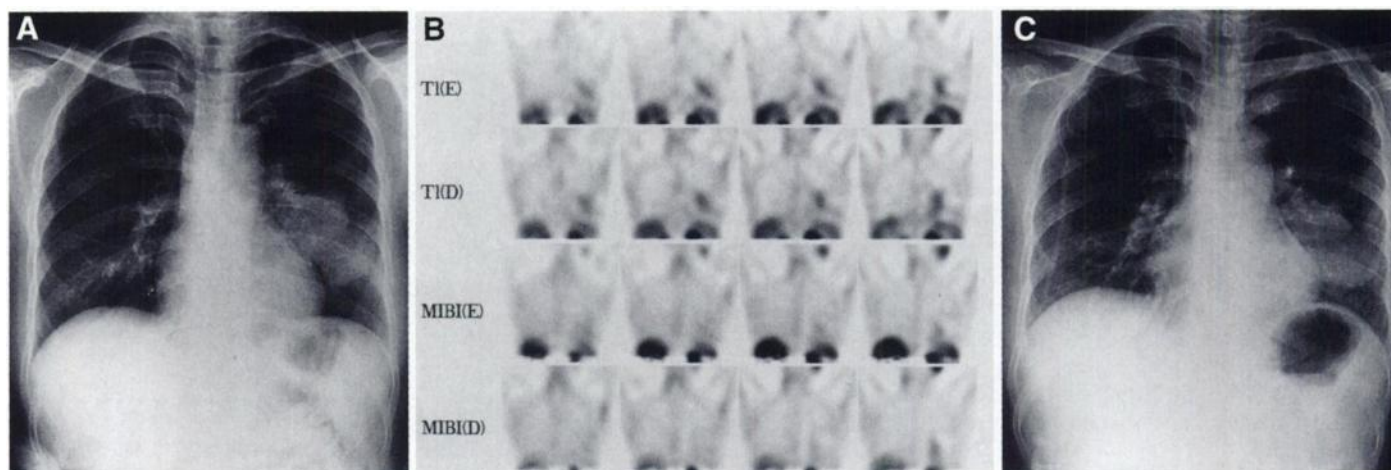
Radiologic findings in Patient 15. (A) Chest x-ray showing a large mass shadow at the lower part of the left lung. (B) Early and delayed images of ^{201}Tl -chloride SPECT demonstrate an abnormal accumulation corresponding to the lesion. Technetium-99m-MIBI SPECT did not demonstrate an abnormal accumulation corresponding to the lesion in either early or delayed images. E = early image; D = delayed image. (C) Chest x-ray after chemotherapy showing no decrease in the size of tumor.
